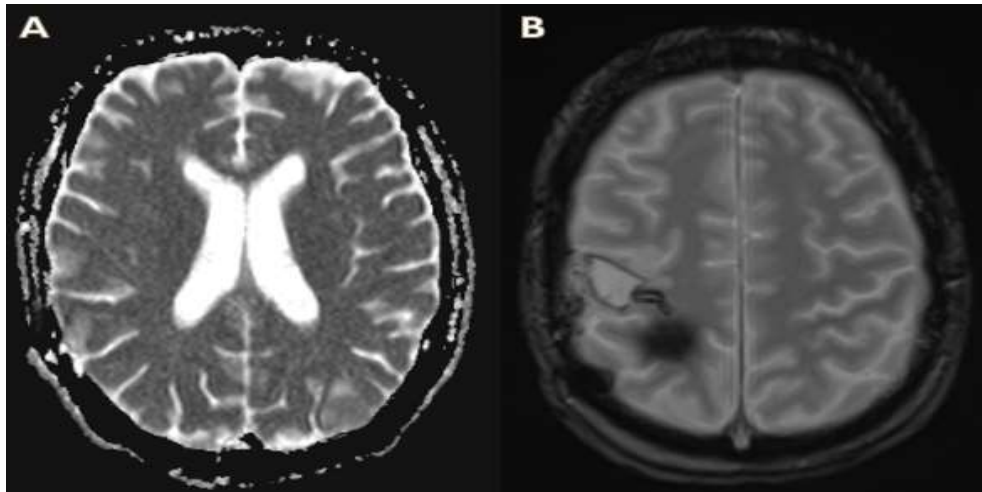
Advanced MRI sequences: (A) ADC map showing facilitated diffusion (high signal) within the lesion, helping differentiate it from hypercellular tumors. (B) Axial T2* sequence revealing peripheral hemorrhagic stigmata (hypointense signal)
